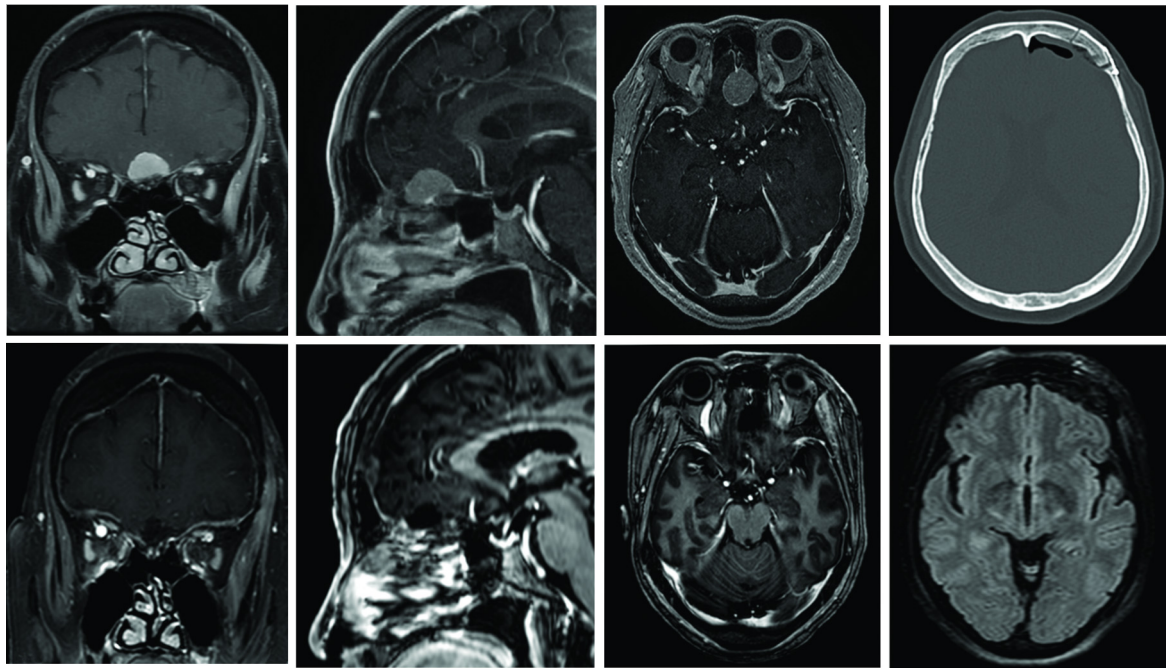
A 68-year-old female presented with progressive periorbital headaches with preserved olfaction. (Top Row) Pre-operative imaging demonstrates an olfactory groove meningioma extending posteriorly to the anterior portion of the planum sphenoidale. The lateral extent of the tumor is confined within the medial aspects of the orbits bilaterally. This tumor is therefore amenable to an endoscopic endonasal transcribriform approach, however, to preserve olfaction we elected to approach this tumor through a left supraorbital eyebrow craniotomy. (Bottom Row) Post-operative imaging demonstrates gross total removal of the meningioma. Top right image shows a post-operative CT scan demonstrating the size of the supraorbital craniotomy. The endoscopic was used to ensure removal of tumor within the depths of the olfactory groove. Axial FLAIR imaging demonstrates no retraction injury to the left frontal lobe. Olfaction was preserved. An endoscopic endonasal transcribriform approach would have guaranteed loss of olfaction and therefore is not the optimal approach.
